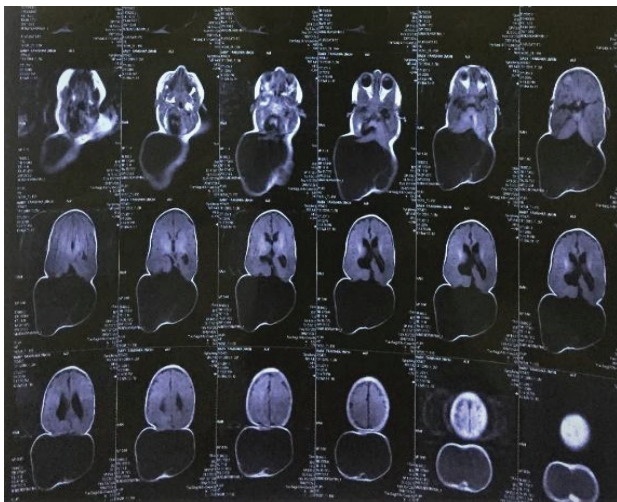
MRI brain with no hydrocephalus associated
